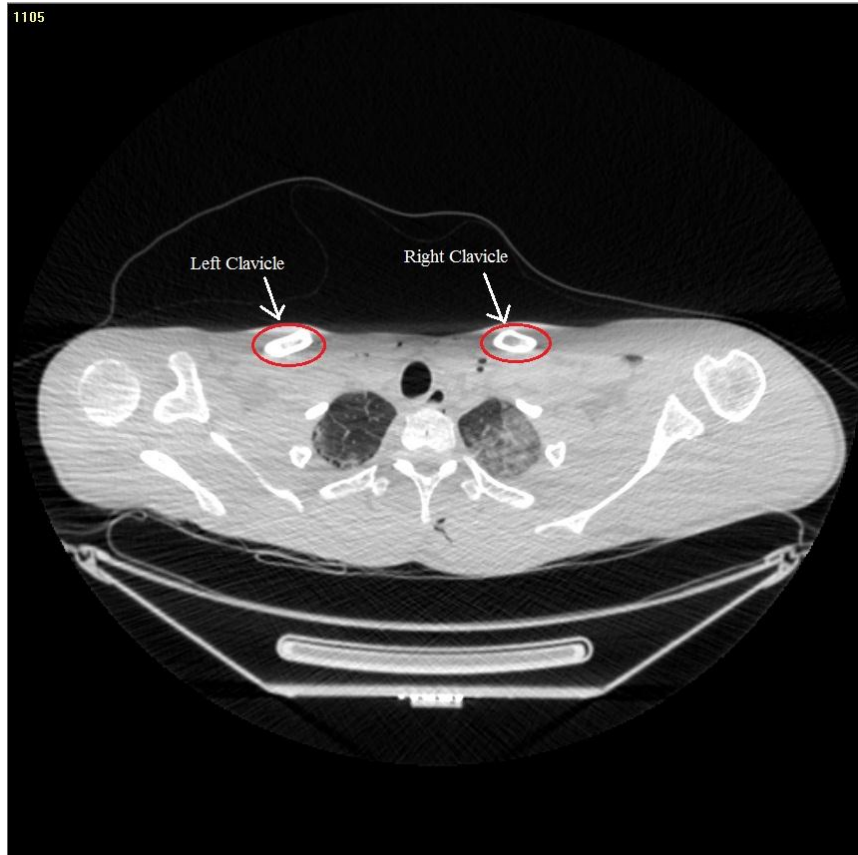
CT Image Slice with Clavicle Labels
